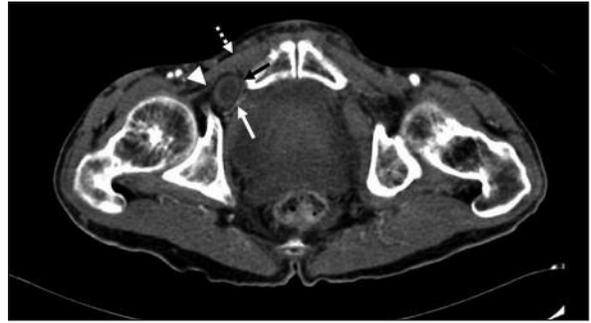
Axial contrast enhanced CT image shows herniated small bowel (black arrow) through the obturator channel. Intestinal structure herniates between external (arrow head) and internal obturator muscles (white arrow). Dotted arrow shows pectineus muscle.
